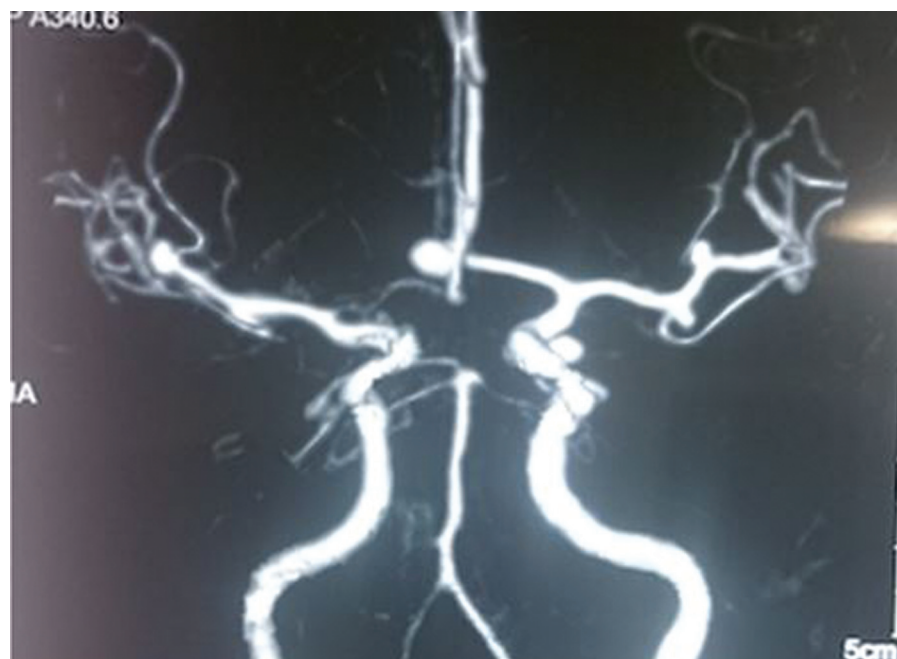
Computed tomography angiography of a 55-year old lady with recent SAH harboring five aneurysms. SAH, subarachnoid hemorrhage.
